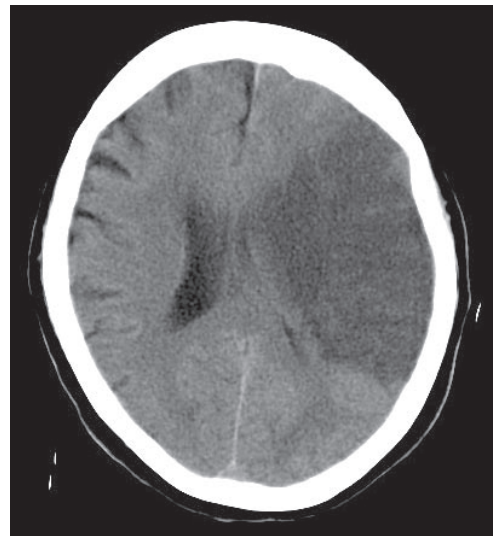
Non-contrast axial CT brain on Day 4.
